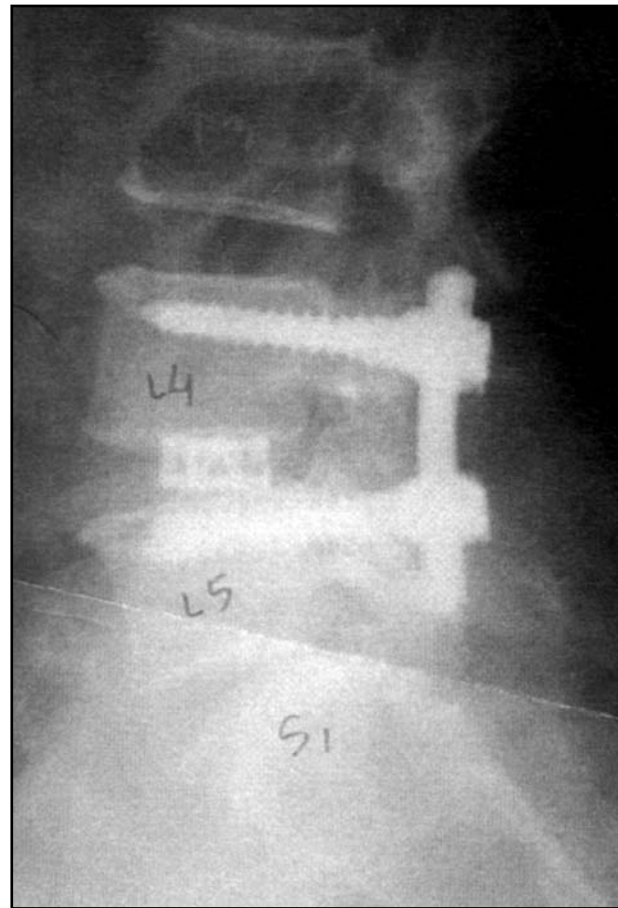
X-ray (P). TLIF (L4-5).
